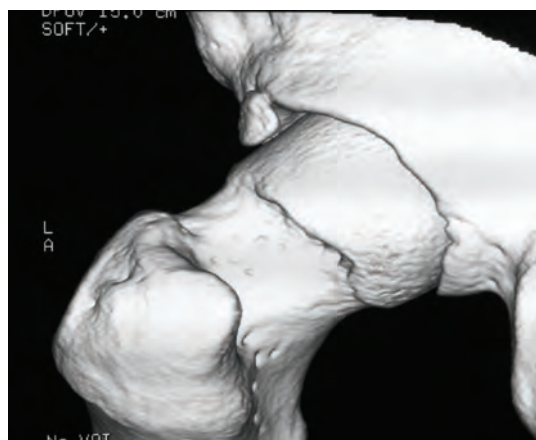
The POD (Pritchard–O'Donnell) “position of discomfort” protocol CT gives surgeons specific 3-dimensional images providing information regarding impingement sites, femoral head–neck morphology and version, acetabular overhang and version, and joint space loss anterosuperiorly
